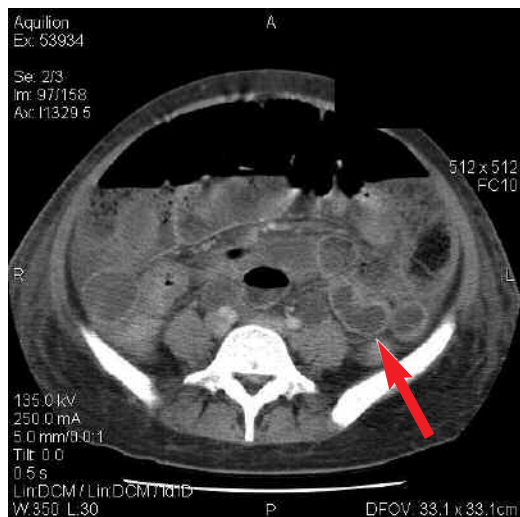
Abdominal computed tomography demonstrating the thickening of the small and large bowel walls.
